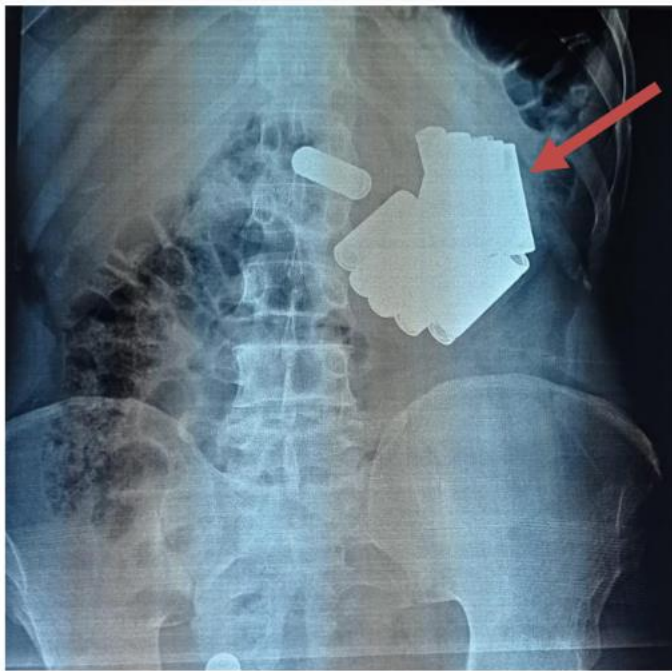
Unprepared abdominal X-ray showing the presence of several piles at the gastric level.
